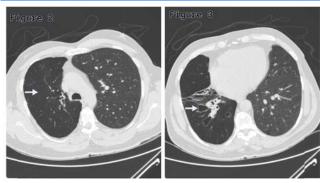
CT section of the chest showing Hyperlucent right lung and attenuated vessels.
